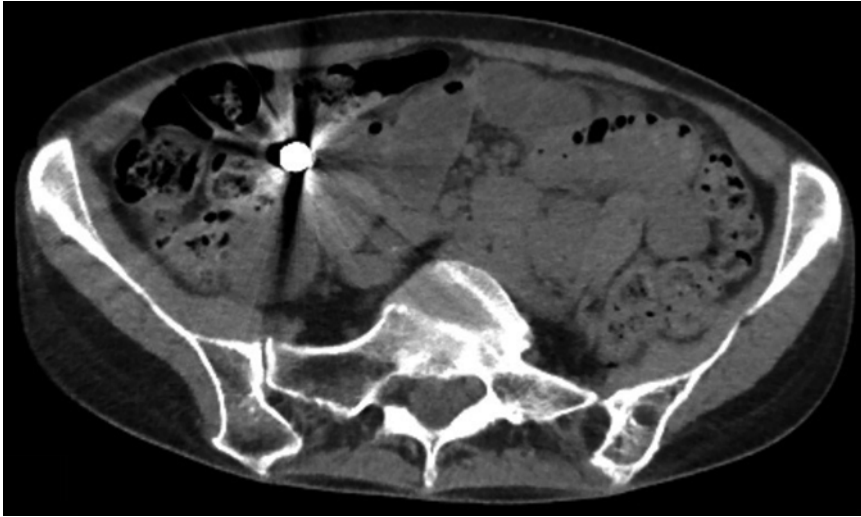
Retained capsule on abdominal CT in a patient with an indeterminate stricture
